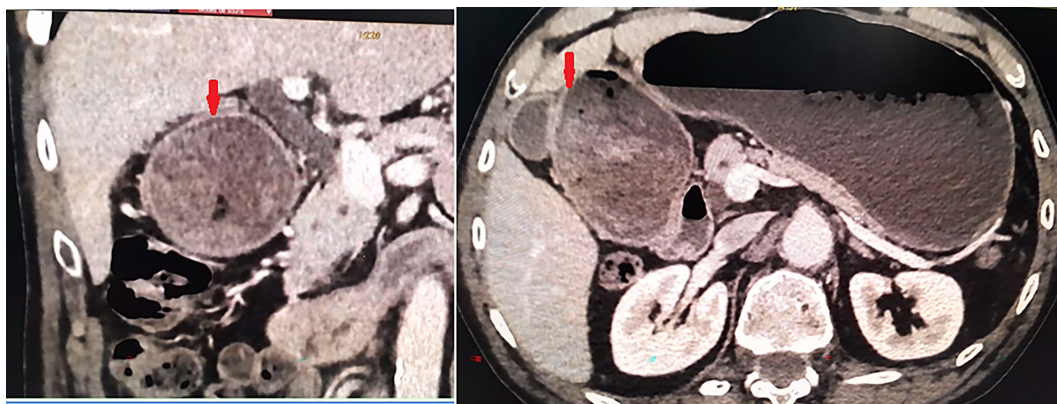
CT slices of the ampullary lesion (red arrow).
